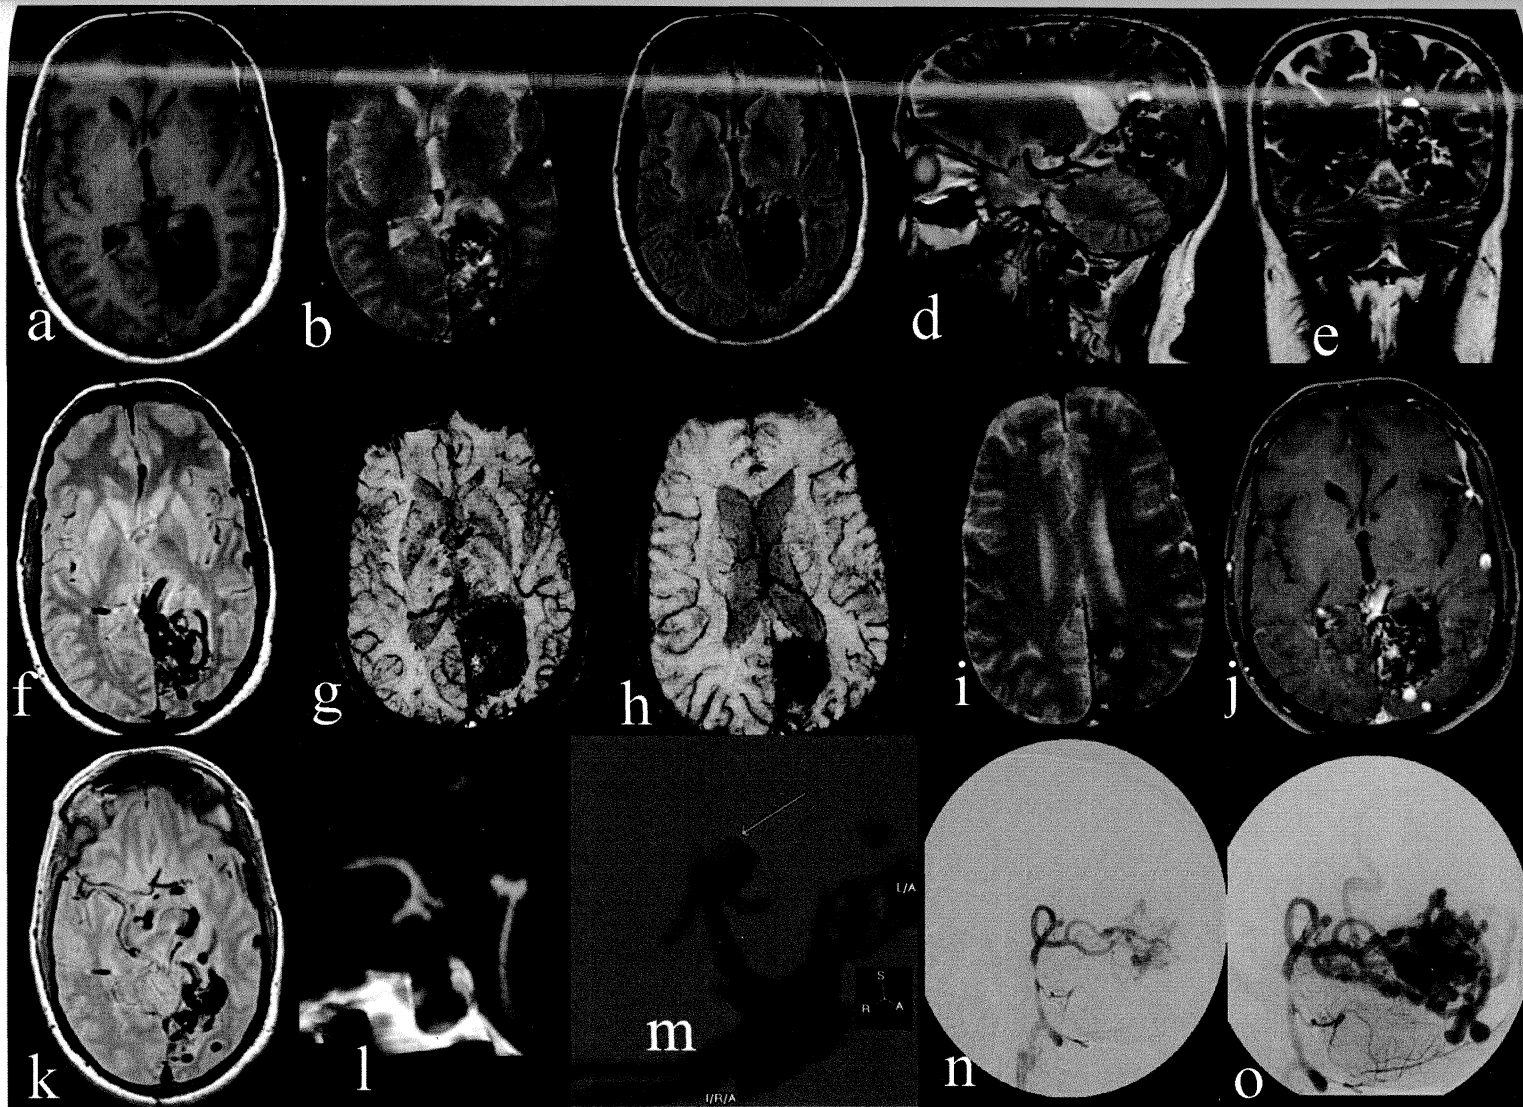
46 year old gentleman, non hypertensive presented with sudden loss of consciousness, papilledema and right homonymous superior quadrantonopia. CT revealed Lt medial occipital hematoma with SAH. MRI routine(a-f), SWI (g, h), 2D GRE (i), and Post contrast Fat saturation T1WI (j) showed a compact nidus in left cuneus and precuneus, fed by left PCA with dilated tortuous veins draining to superficial and deep veins. There was e/o chronic SAH and ICH in left parietal lobe on SWI (g, h). Proton Density axial MRI (k), CTA 3D reconstruction(l, m) and DSA (n, o) revealed the above morphology as well as a saccular flow related basilar top aneurysm.
